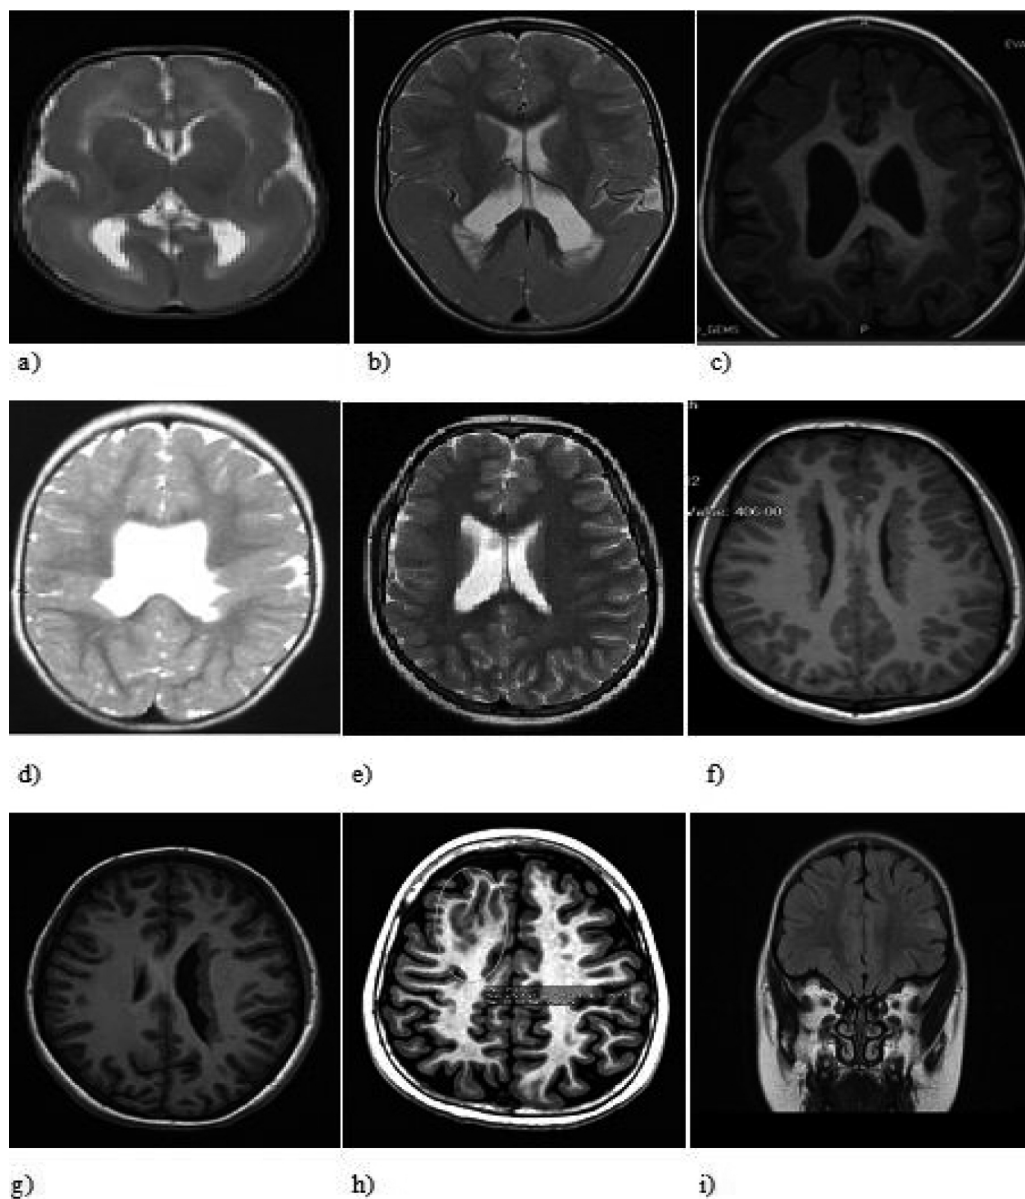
MRI of cortical malformations: a) Axial T2-weighted MRI slice of diffuse agyria with few shallow sulci in the frontal area; b) Axial T2-weighted MRI slice of parieto-occipital agyria; c) Axial T1-weighted MRI slice of bilateral subcortical band heterotopia; d) Axial T2-weighted MRI slice of bilateral closed schizencephaly associated with septo-optic dysplasia; e) Axial T2-weighted MRI slice of right-sided polymicrogyria; f) Axial T1-weighted MRI slice of bilateral periventricular nodular heterotopia; g) Axial T1-weighted MRI slice of unilateral periventricular nodular heterotopia; h) Axial T1-weighted MRI slice of focal cortical dysplasia in the right frontal area; i) Coronal view of FLAIR MRI slice of cortical dysplasia in the area of the left lower frontal gyrus
